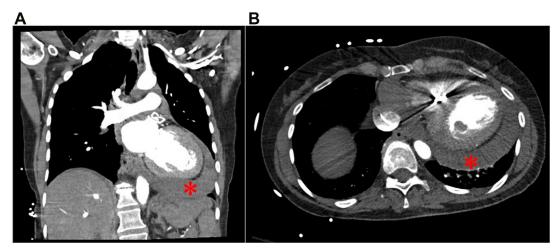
Chest computed tomography scan showing large pericardial effusion (red asterisk). A: Coronal view. B: Transverse view.
